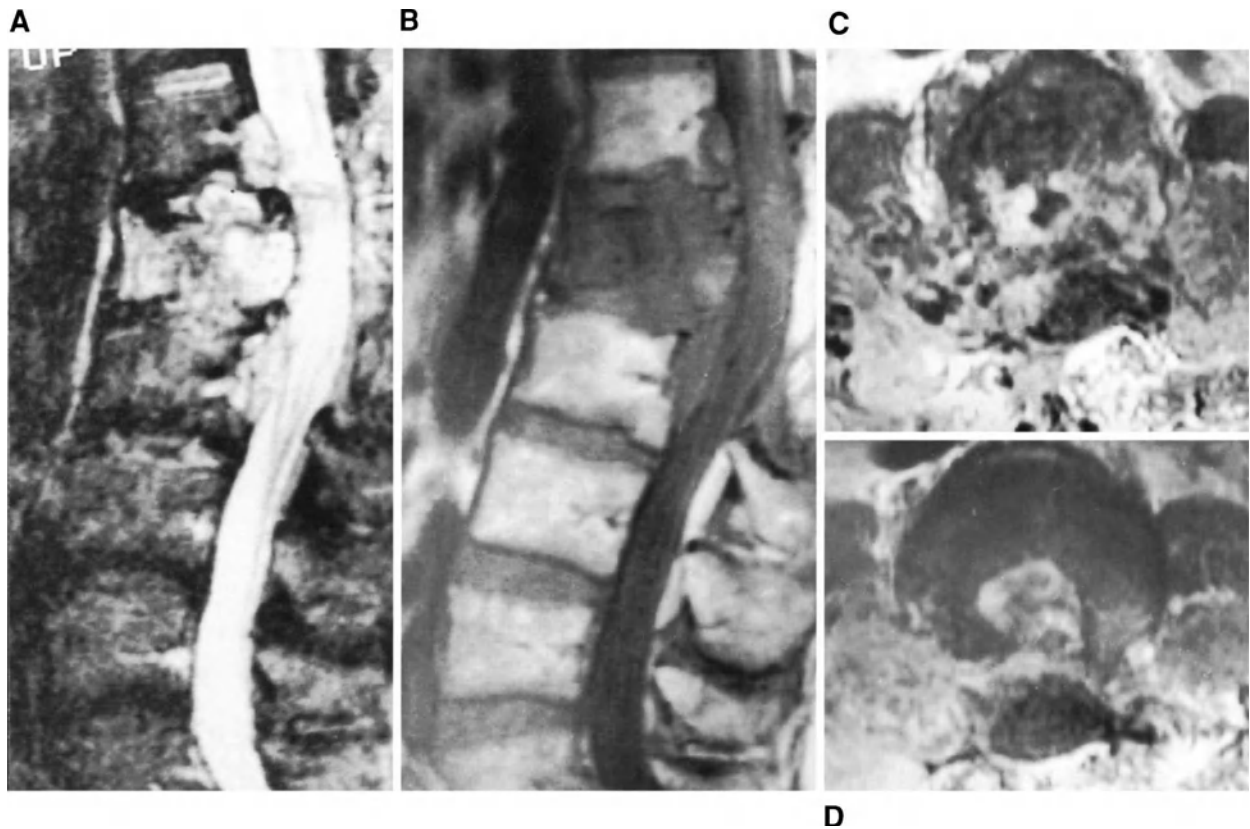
MR images showing a L2 chordoma. (A) Sagittal T2-weighted spin-echo image. (B) T1-weighted spin-echo image. (C) and (D) Axial T1-weighted spin-echo postgadolinium images. Large lesion, markedly hyperintense on the T2-weighted image, destroying the vertebral body. The thecal sac is compressed by the neoplasm, which invades extensively the anterior epidural space.
